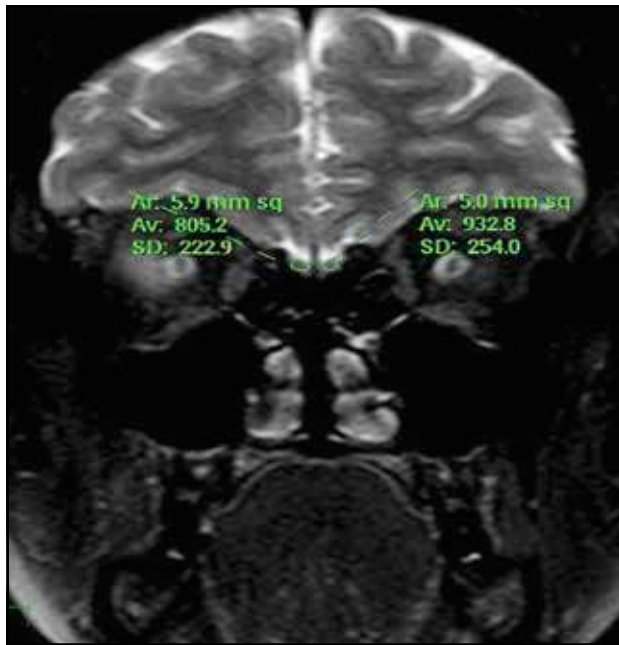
On coronal T2W FSE MRI image, OB volume measurements are shown.
